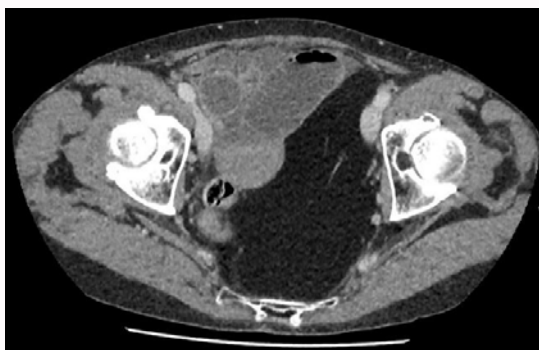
Axial view left-posterior intra-pelvic lipoma on CT AP.
